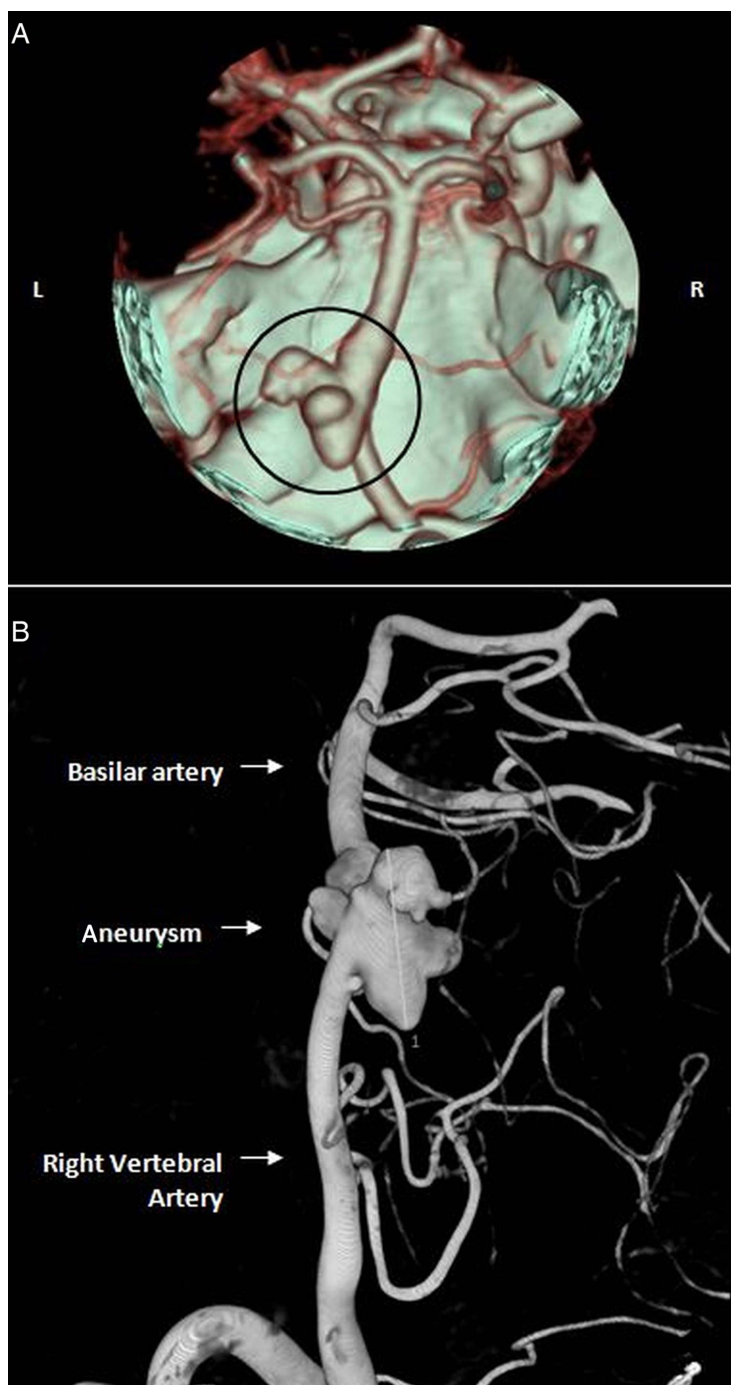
Three-dimensional images showing complex, multilobular, fusiform aneurysmal dilation of right vertebrobasilar junction. (A) CT and (B) cerebral angiography.
